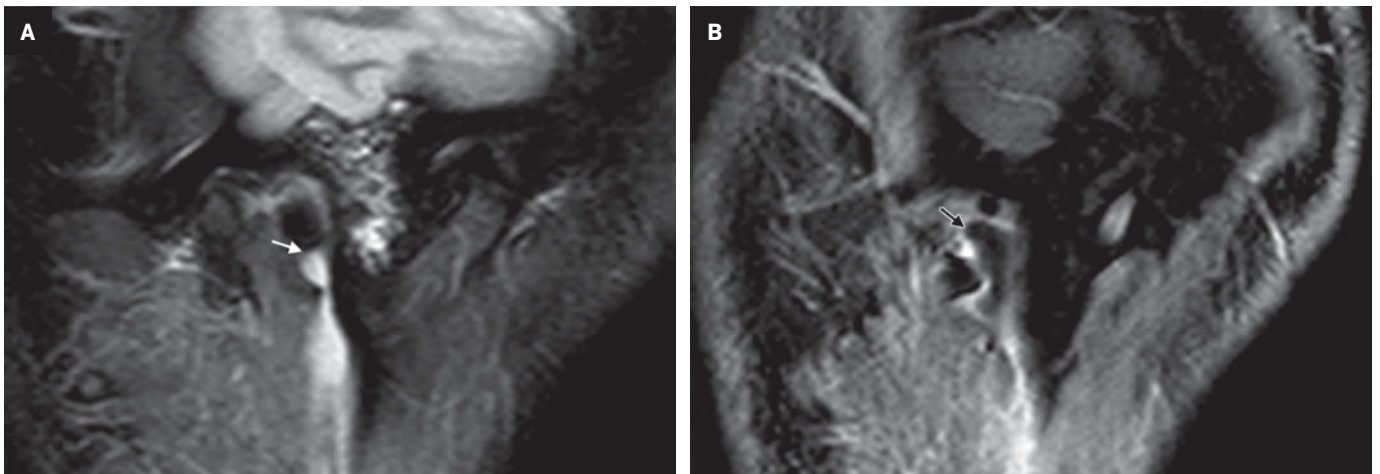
Sagittal MRI. Both T2 sequences (A, white arrow) and gadolinium-enhanced T1 sequences (B, black arrow) demonstrate the fistulous tract ending at the posterior aspect of the EAC.
